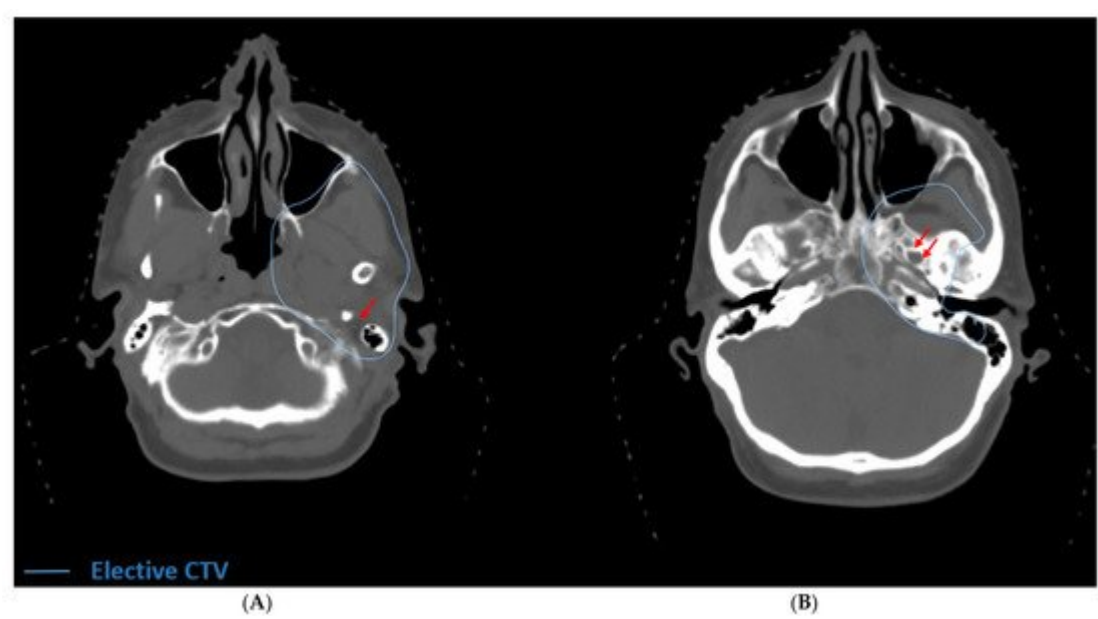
Definitive radiation for unresectable ACC of the deep lobe of the parotid with PNTS. (A) The elective volume includes the stylomastoid foramen (red arrow). In this case, there was extension into the parapharyngeal space and infratemporal fossa. (B) The elective volume includes the foramen ovale (double red arrows) because of radiographic involvement of V₃. In this case the elective volume was treated to 56 Gy.
